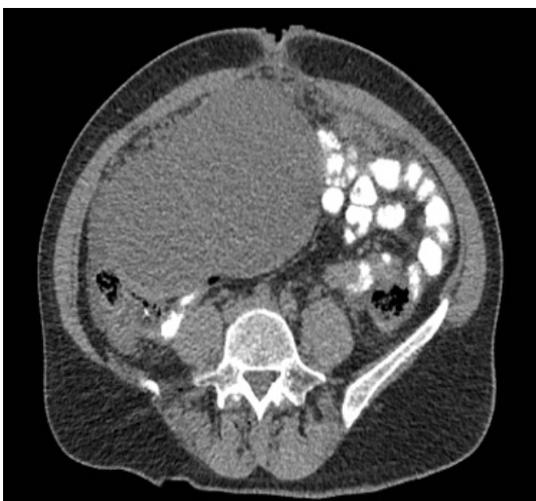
CT of abdominal cavity and pelvis with signs of tumor propagation to the front (transversal view)
